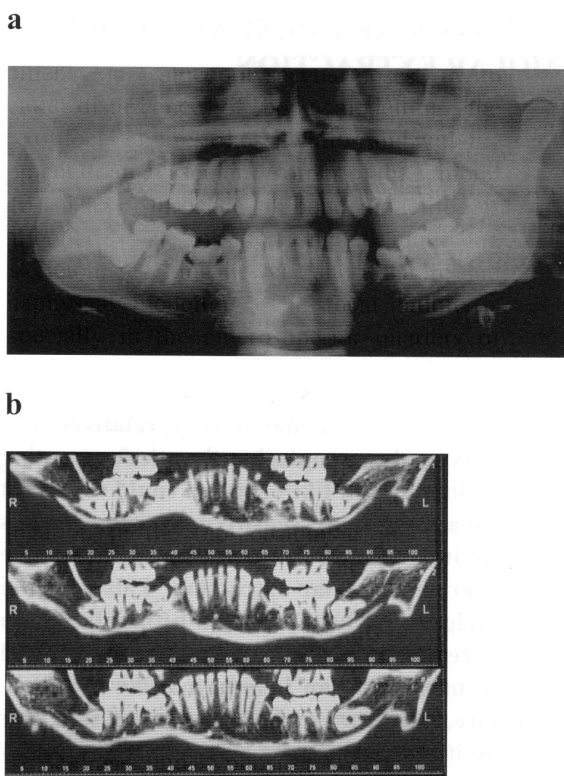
a,b) Orthopantomography and CT images for the correct evaluation before deep-impacted lower third molar extractions.
